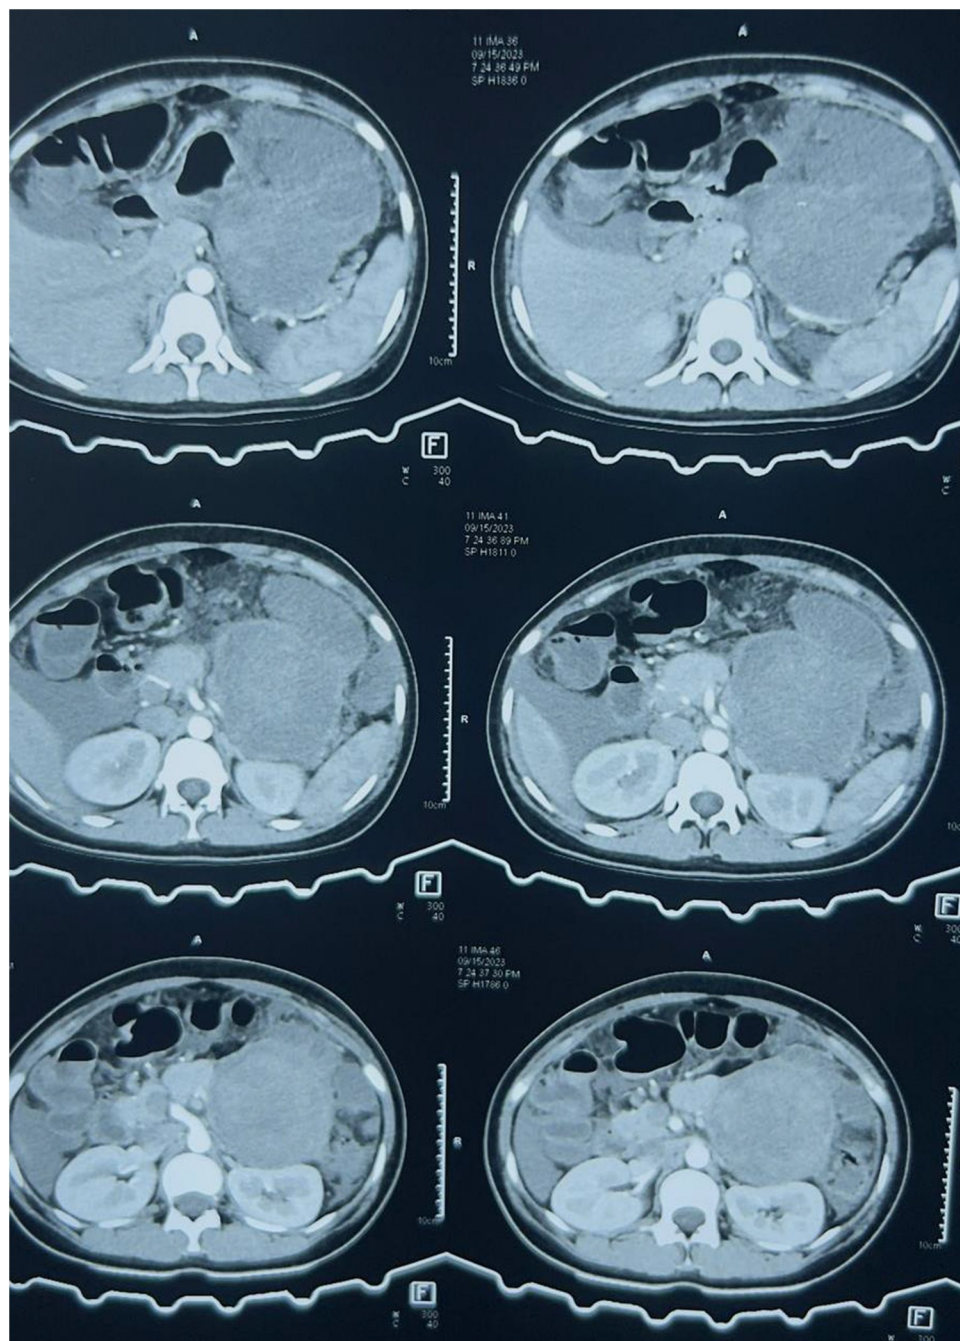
Computed tomography scan of abdomen showing solid pseudopapillary tumor of pancreas.
